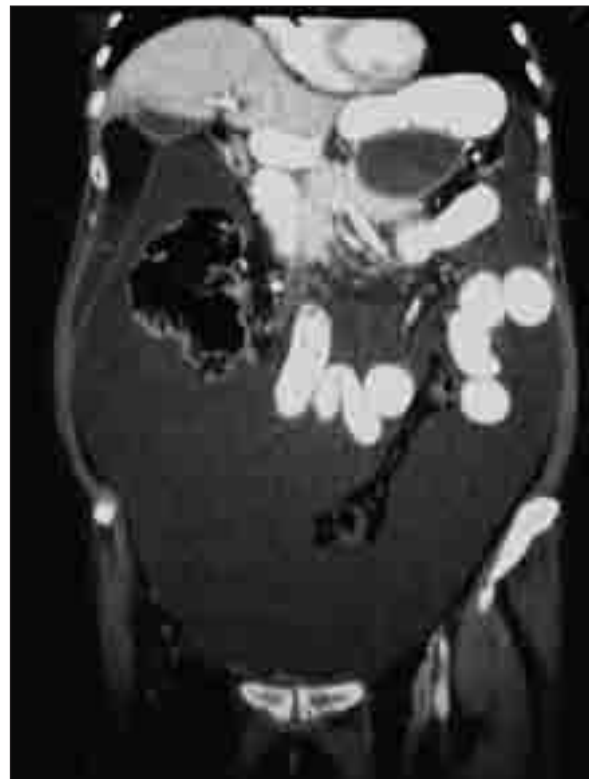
CT scan coronal image shows abundant abdominal ascites with septa (arrow) and fluid-fluid level of differential density due to layering of the chylous fluid.
